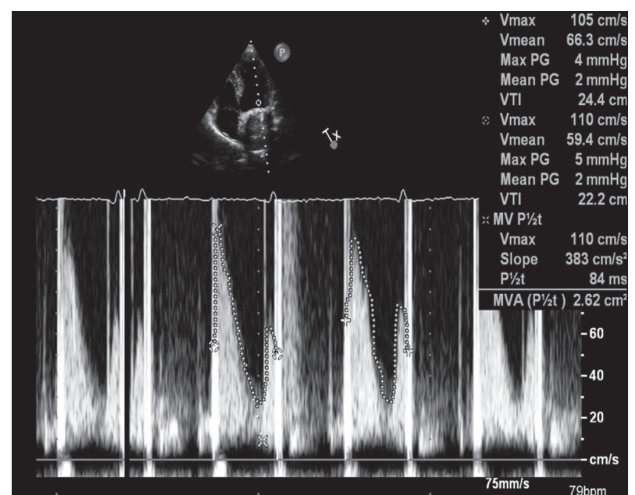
The transthoracic Doppler echocardiogram was showed an excellent working prosthetic mitral valve, with gradients of 5/2 mmHg (maximum/mean), valve area 2.62 cm².
